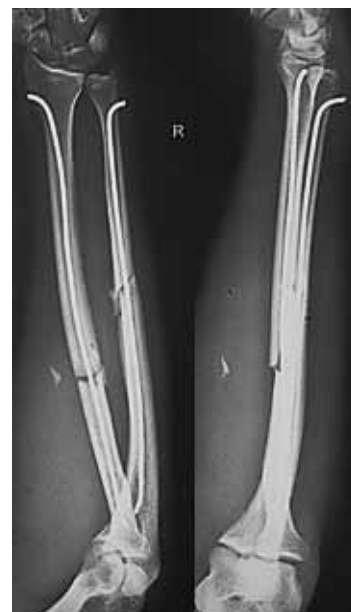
The same patient. Control X-ray
